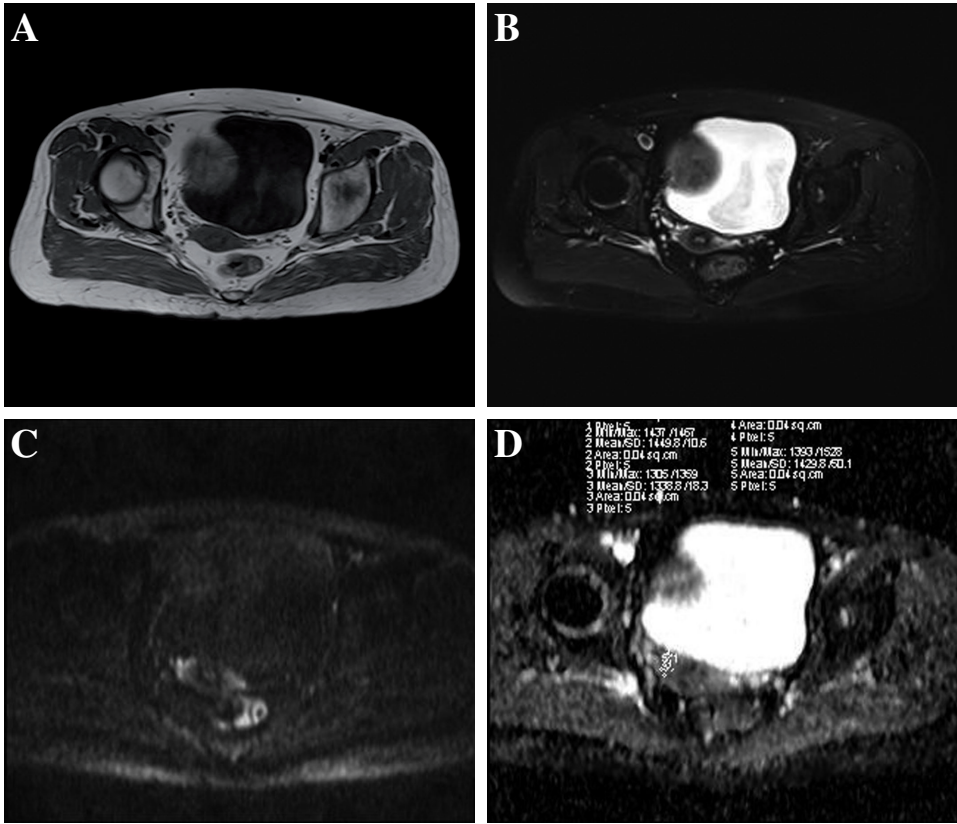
MRI and ADC features in the normal cervical tissue. A: T1-weighted image shows homogeneous iso-intensity with inconspicuous delamination in cervical tissue. B: Fat-suppression/T2-weighted image shows the cervix from outside to inside: (1) medium intensity of outer zone, (2) obvious hypointensity of binding zone, (3) obvious hyperintensity of internal zone, (4) mucilage in the cervical canals which has similar hyperintensity with the mucosa of internal zone. C: DWI image shows the four structures in the cervix which is similar to the image in T2WI. D: In the ADC map, the ROIs were measured five times in the right side of cervix and the mean value of ADC was $1.378 \times 10^{-3} \text{ mm}^2/\text{S}$.
